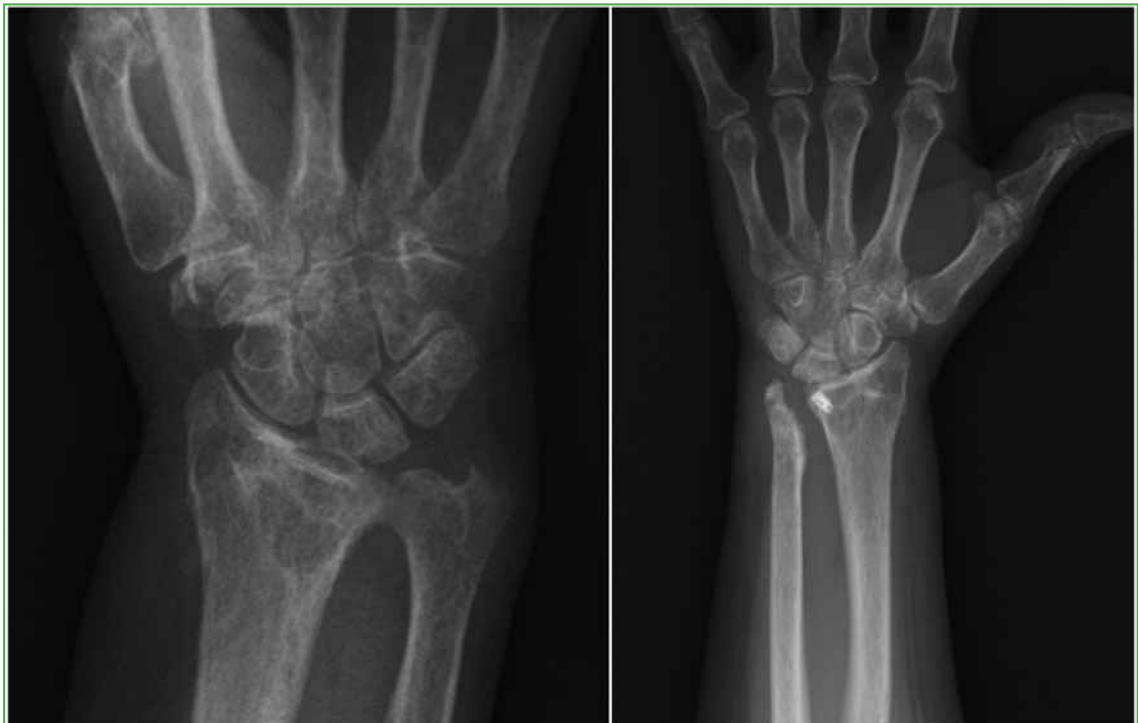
Wrist radiographs, AP view. A. Preoperative. B. Postoperative.
